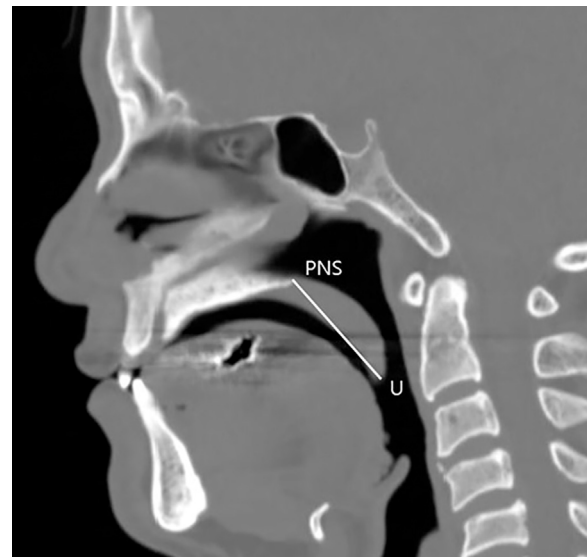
Measurement of soft palate length on a computed tomography sagittal plane scan. PNS, posterior nasal spine; U, uvula.
